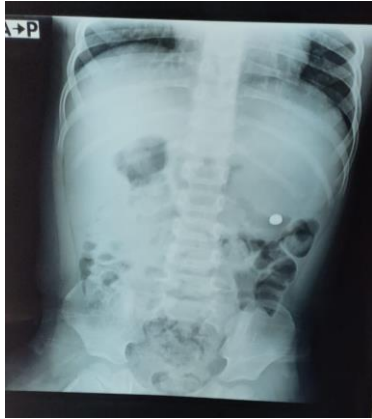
Abdominal X-Ray showed visible foreign body in the stomach.
